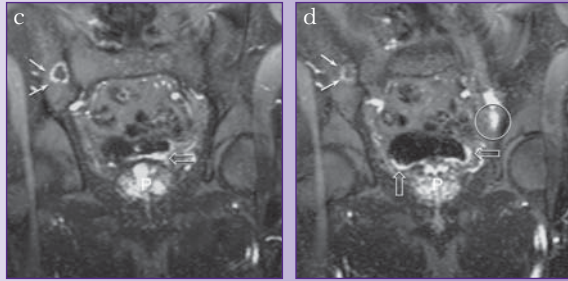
Patient with invasive bladder cancer (stage T3B), with nodal and bone marrow metastases. (a) and (b) Coronal T1-weighted fast Flash images show enlarged prostate (P), enlarged node (circle) and bone marrow lesion
